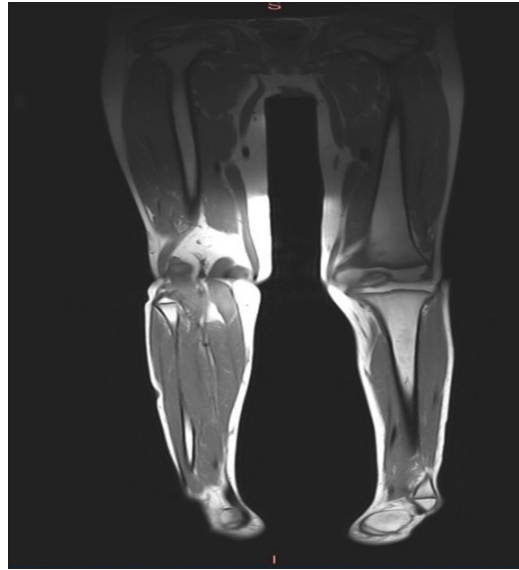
T1-weighted MRI of lower limbs demonstrating soft tissue and muscular hypertrophy of right lower limb.
